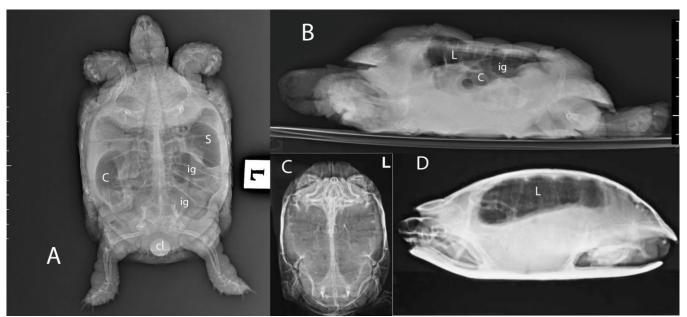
Dorsoventral (A) and lateral with horizontal beam (B) radiographs from whole body of the tortoise. Note the depression of the shell and compression of the lungs, the increased intestinal gas, prominent cloaca, and all appendages outside the shell due to lethargy. C and D: Normal dorsoventral and lateral radiographs of a conscious red eared terrapin (*Trachemys scripta*), note the appendages inside the normal arched shape shell.³ L; Lungs, C; Colon, ig; Intestinal gas, cl; Cloaca, S; Stomach.
